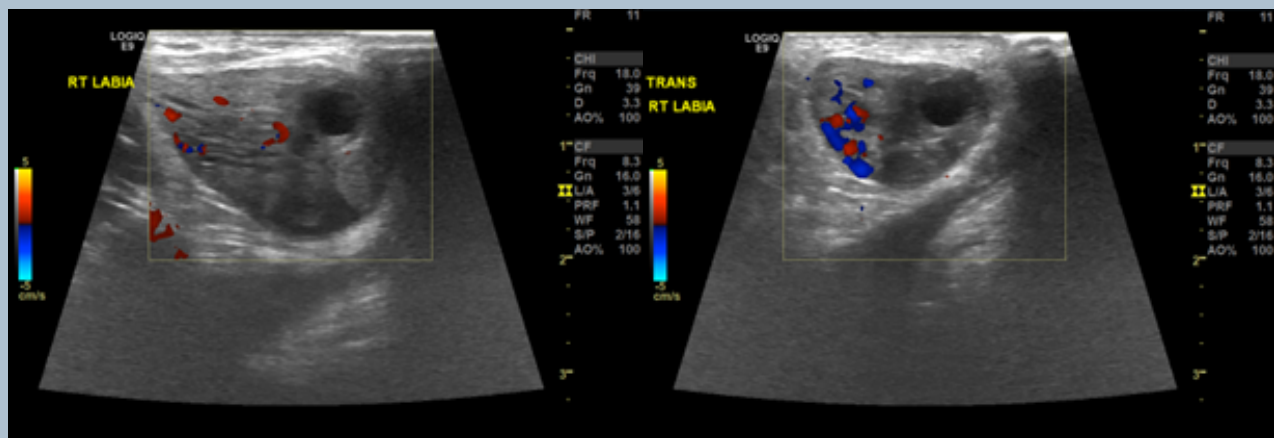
Color Doppler reveals adequate blood flow to the herniated ovary.
